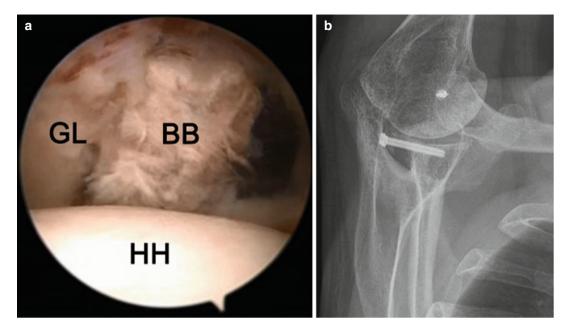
Arthroscopic posterior bone block augmentation (a). Postoperative Bernageau radiographic view (b)
